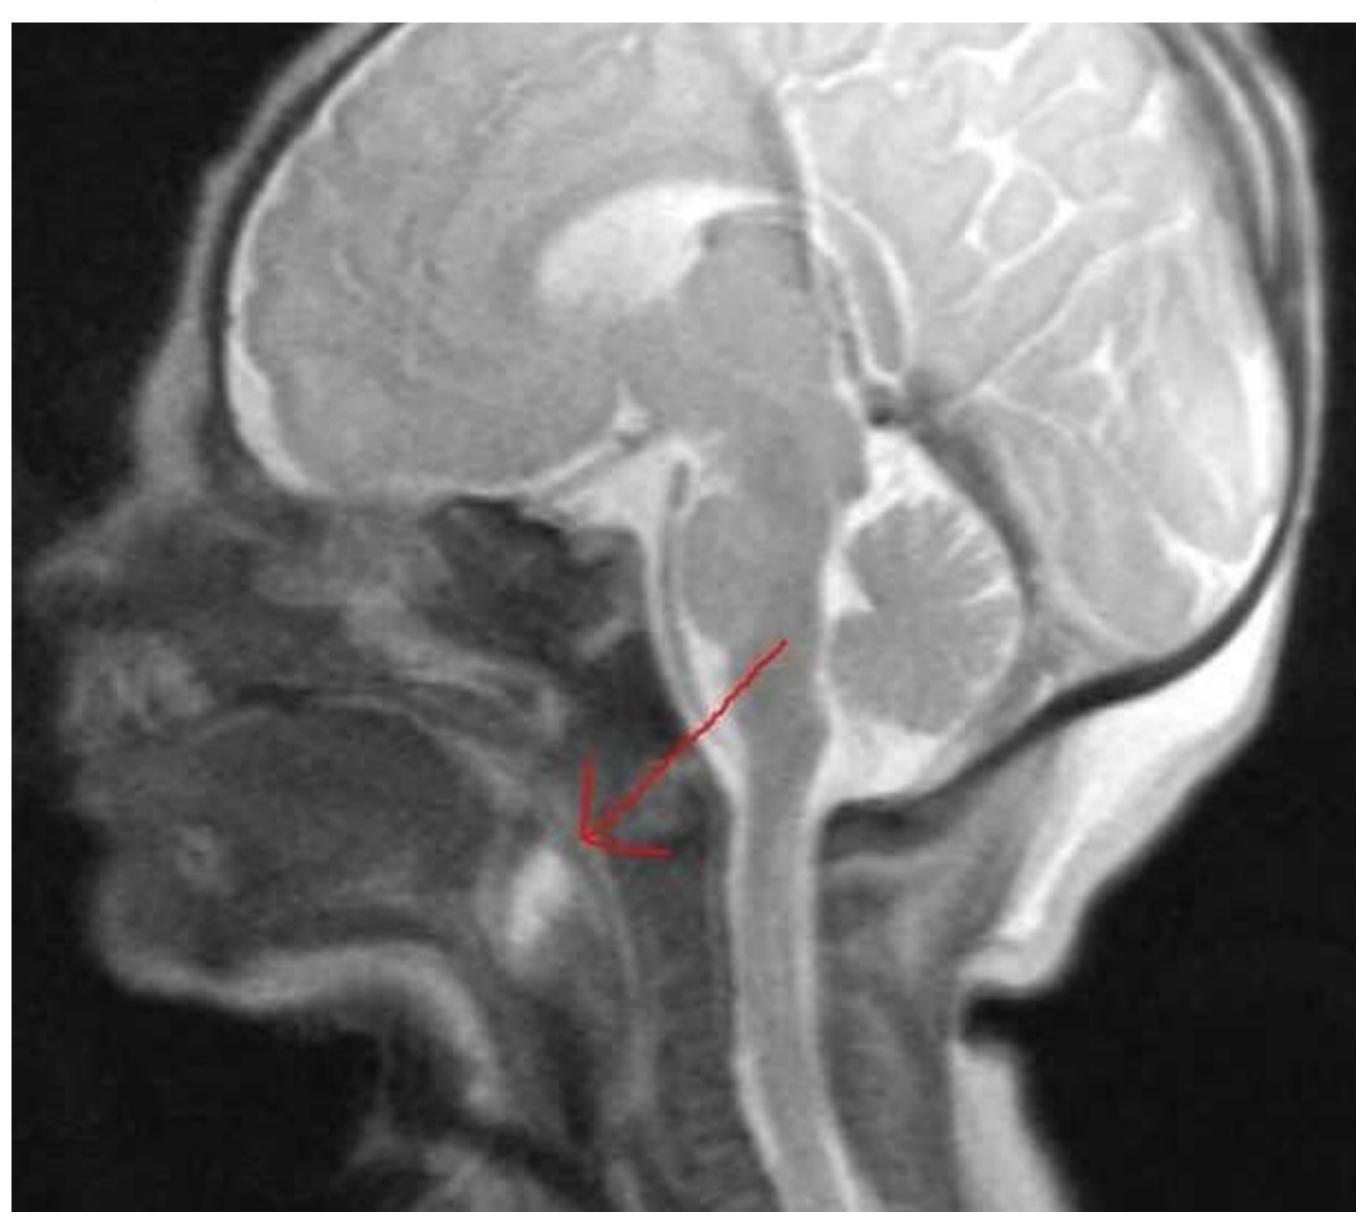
Pre-excision MRI: Note the near-total obstruction of the airway by the mass. Note the in situ tracheostomy tube.
